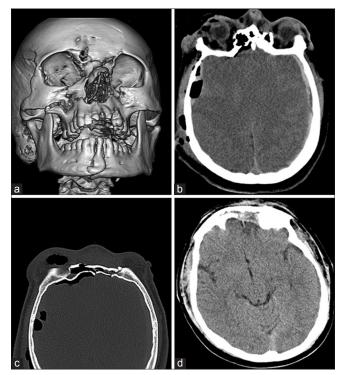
Case I. (a) Three-dimensional recontruction showing the injury pattern and extensive facial trauma suffered by this 17-year-old male. (b) Axial head computed tomography (CT) scan demonstrating bilateral subdural hematomas with associated cerebral edema and moderate amount of pneumocephalus. (c) Axial CT scan of the facial bones displaying a comminuted fracture through the frontal sinus with disruption of the anterior and posterior tables. The degree of displacement is less than full width. There is associated nasofrontal outflow tract obstruction and moderate right frontal pneumocephalus. (d) Postoperative axial head CT scan demonstrating interval resolution of the subdural fluid collections as well as successful cranialization of the frontal sinus
